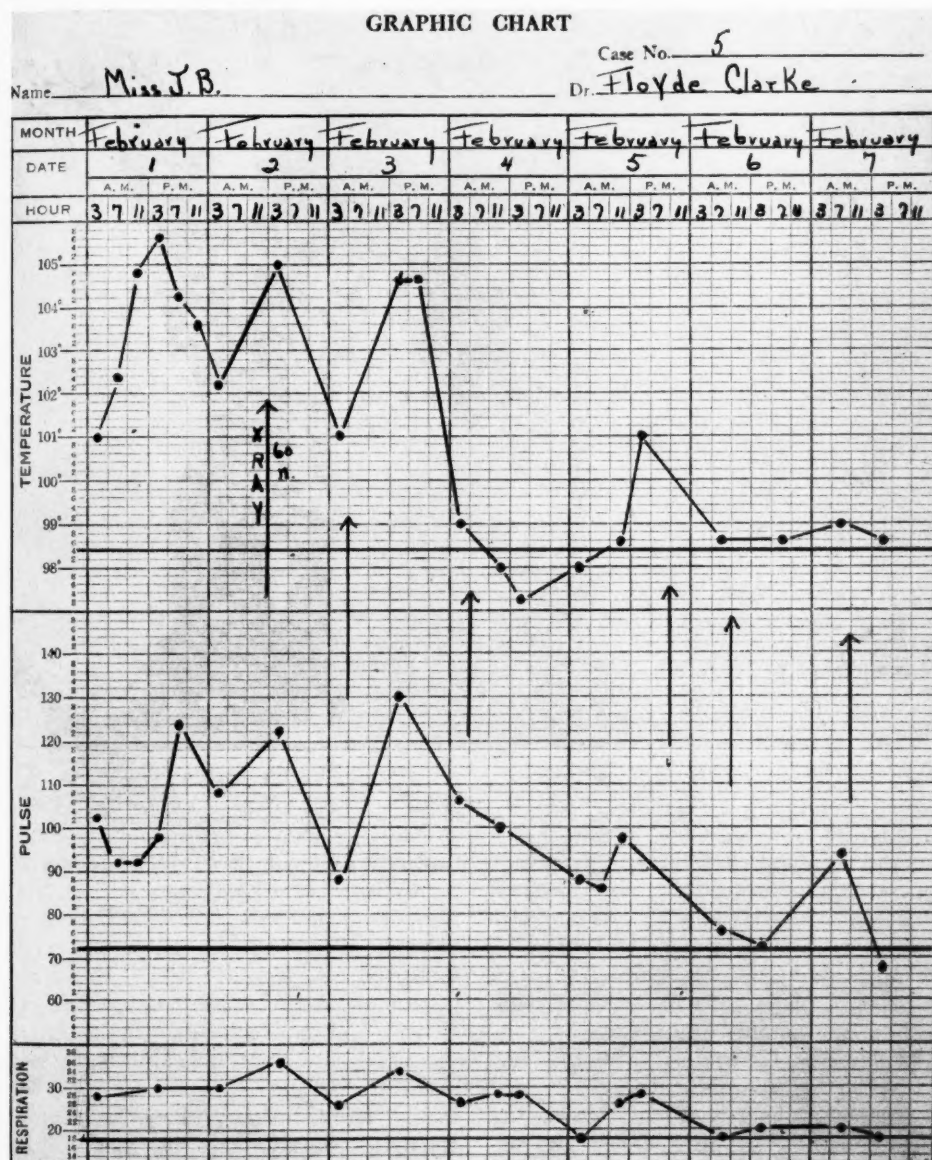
Case 5. Diagnosis: lobar pneumonia. X-ray technic: kv, 110; ma, 5; distance 50 cm.; filter 3 mm. Al; r units, 60 per treatment, total 360; port, entire chest anteriorly; result, excellent.
